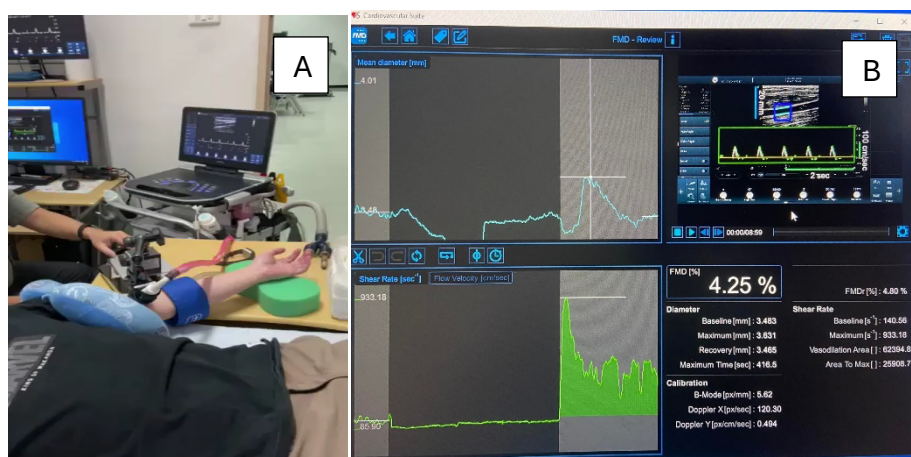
Flow-mediated dilation (FMD) test: (A) Ultrasound measurement of brachial artery diameter is performed at baseline, followed by occlusion with a blood pressure cuff inflated to 200 mmHg (or ≥ 50 mmHg above systolic BP) for 5 minutes. After cuff release, the reactive increase in arterial diameter and blood flow was recorded to calculate the FMD value; (B) Cardiovascular Suite™ software was used to analyze vessel wall changes and calculate the FMD results.
